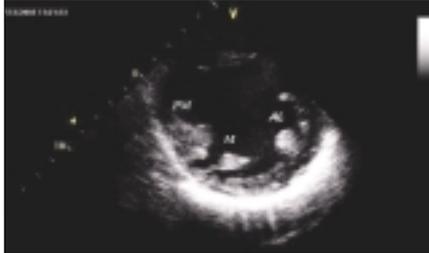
Parasternal short-axis view of three papillary muscles (anterolateral (AL), middle (M) and posteromedial (PM) papillary muscles showed by arrows)
